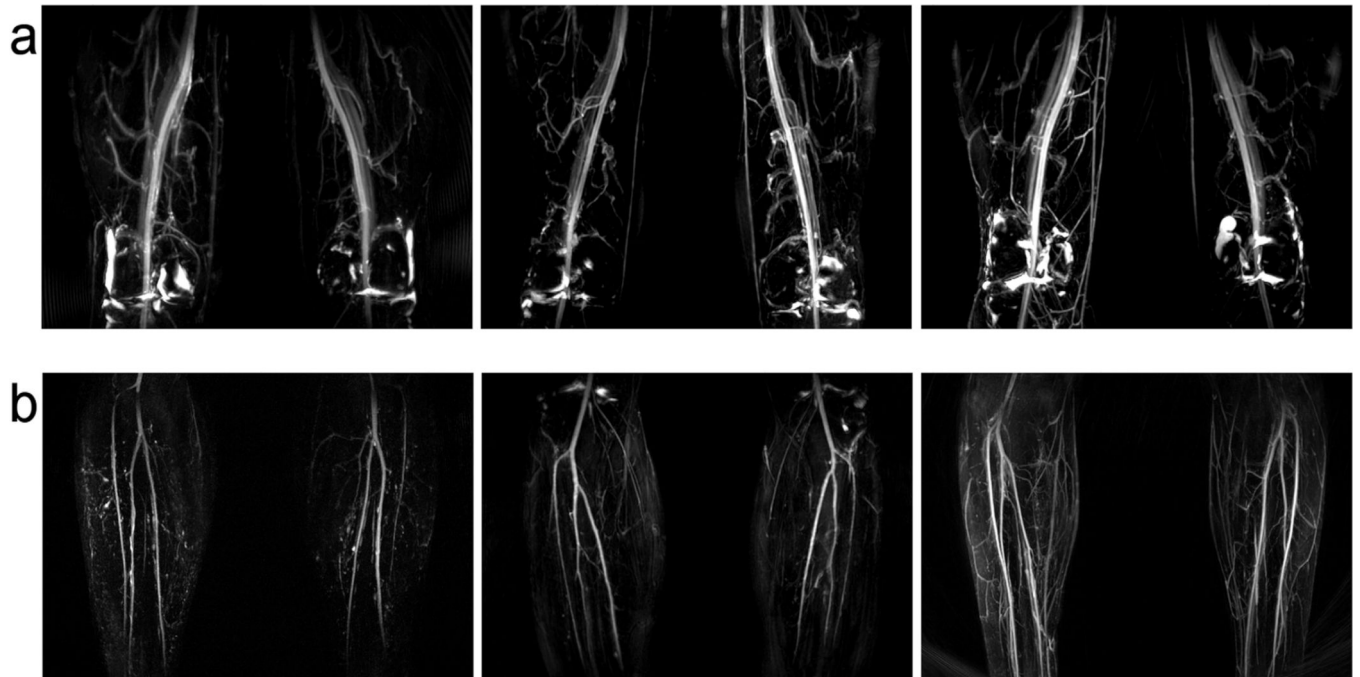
Volunteer data. All volunteers were scanned with the same protocol. a: Thigh station; synovial fluid is observed in the knee where a FLAIR pulse was not applied. b: Calf station; acquired with modest undersampling to improve resolution.
